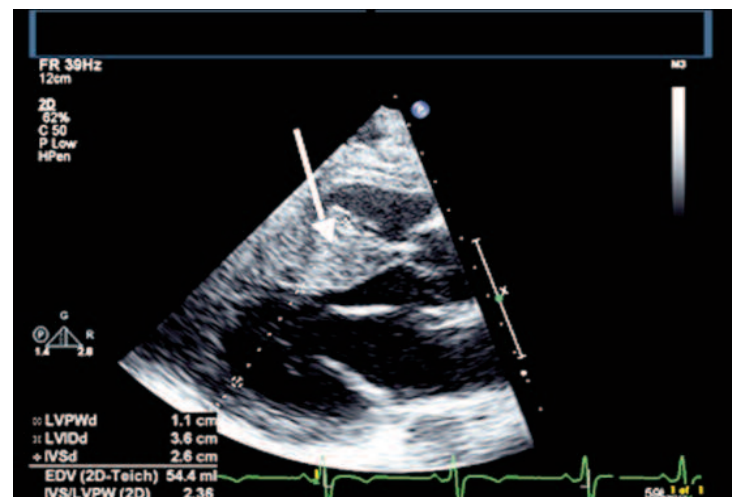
Transthoracic echocardiogram showing marked asymmetrical septal left ventricular hypertrophy (white arrow).
